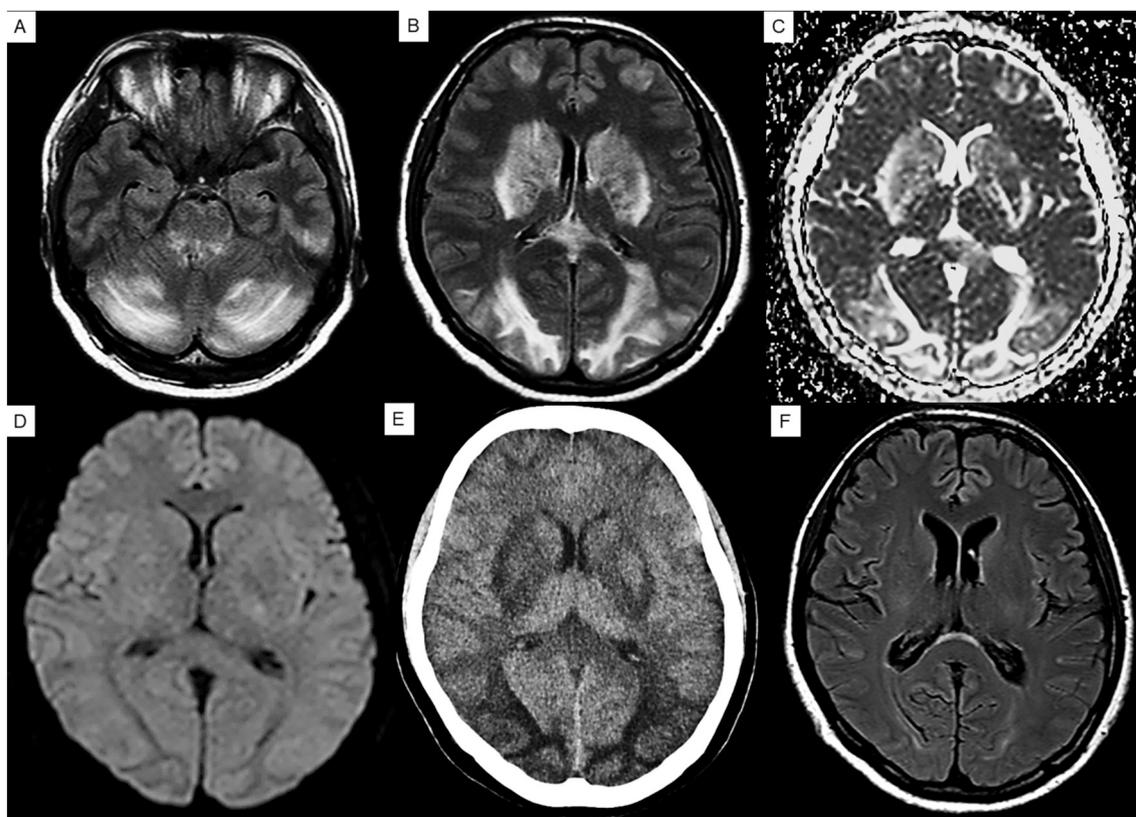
Atypical MRI findings in PRES. A 38-year-old pregnant woman was admitted as an emergency case with a complaint of upper abdominal pain and headache at 29 weeks of pregnancy and development of HELLP syndrome. MRI shows hyperintense signal lesions in the cortical and subcortical white matter bilaterally in the cerebellar hemispheres (A) and in the occipital lobes, basal ganglia, and callosal splenium in both the fluid-attenuated inversion recovery sequence (B) and apparent diffusion coefficient mapping (C), but these lesions are not recognized in diffusion-weighted images (D), and CT shows hypointensity in the same lesions (E). The follow-up brain MRI performed 2 weeks later shows complete resolution of the lesions (F).
